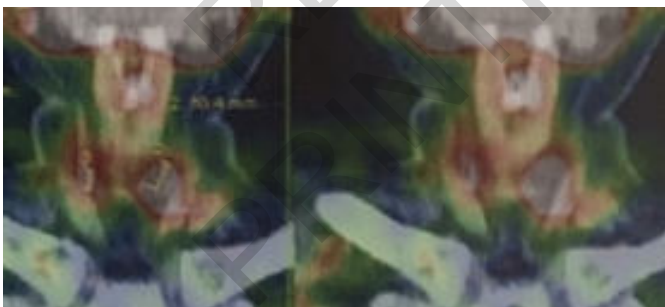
SPECT-CT – a small parathyroid tissue at the site of the previous operation with SUV 5.6 and a diameter of 6.8 mm, and a single enlarged parathyroid gland contralaterally with a diameter of 7.2 mm and SUV 14.6.
